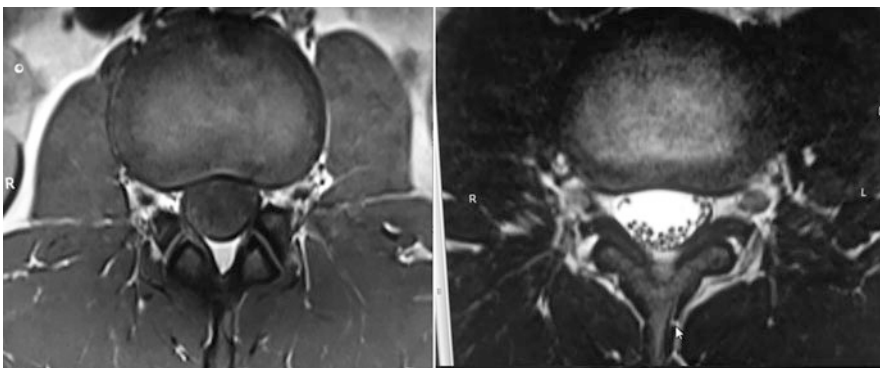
MRI: note the far clearer delineation of all structures compared to Fig. 3; disc, canal, and nerve roots
